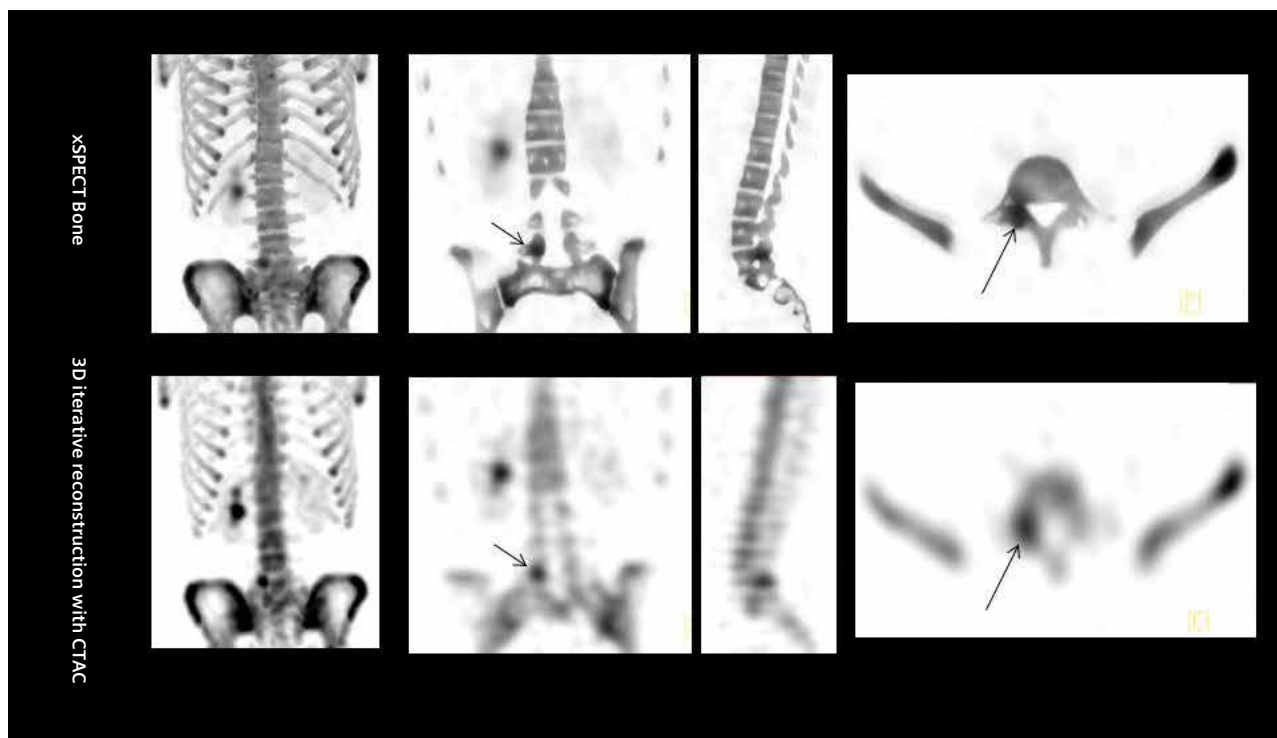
Comparison of 3D iterative reconstruction and xSPECT Bone reconstructions show sharper delineation of the focal area of increased tracer uptake in the right side of the L5 vertebrae, located at the right edge of the lamina. xSPECT Bone sharply delineates the focal hot area and clearly localizes it to the pars interarticularis at the right edge of the right L5 lamina, and in close proximity to the superior articular process.
